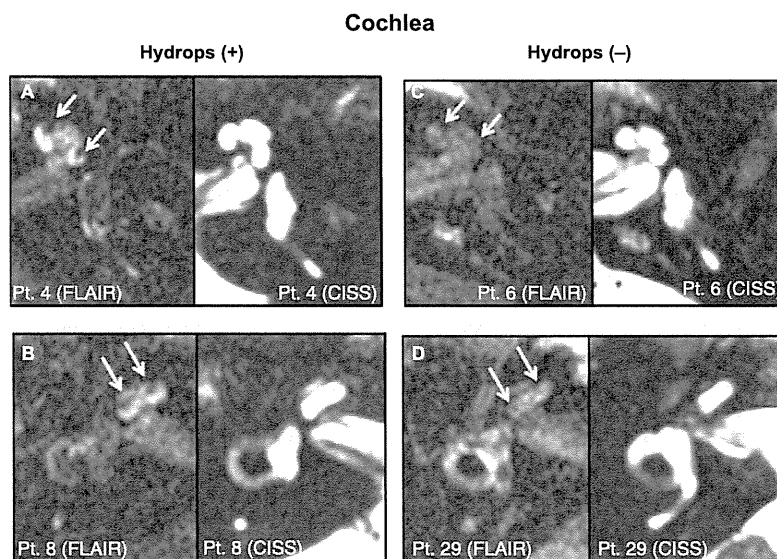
Hydrops-positive (A and B) and hydrops-negative (C and D) cochlea in 2D-FLAIR and CISS images. (A and B) 2D-FLAIR images show enlarged scala media of basal turn (arrows); endolymphatic hydrops is seen as scallop-like shape with low or no signal intensity area surrounded by perilymphatic spaces showing high signal intensity area due to gadolinium enhancement. (C and D) 2D-FLAIR images: no remarkable low signal intensity area was found in cochlear basal turns (arrows). CISS images in the same plane were helpful in identifying inner ear structures. Numbers in the figures indicate patient ID numbers.
